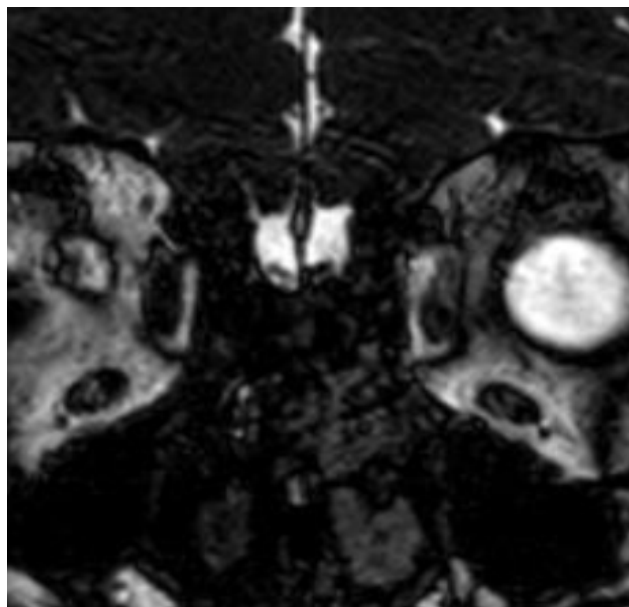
Coronal T2 MRI demonstrates olfactory bulb of male pt 40 ys old shows bilateral decreased OB volume.
